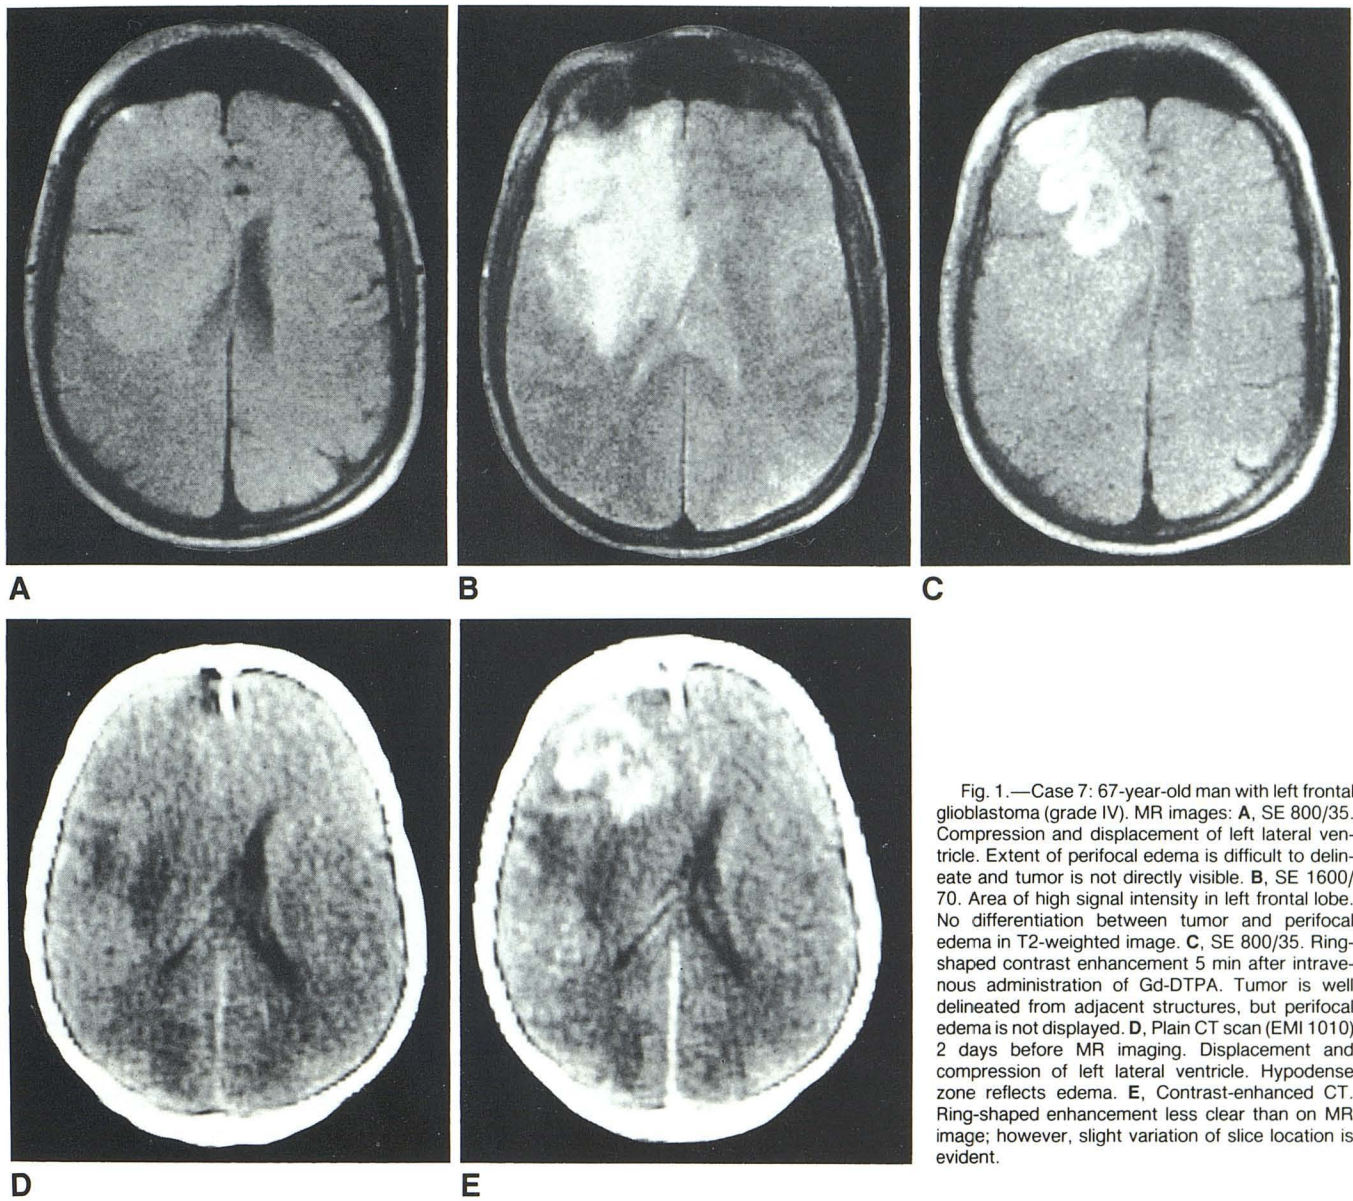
Case 7: 67-year-old man with left frontal glioblastoma (grade IV). MR images: A, SE 800/35. Compression and displacement of left lateral ventricle. Extent of perifocal edema is difficult to delineate and tumor is not directly visible. B, SE 1600/70. Area of high signal intensity in left frontal lobe. No differentiation between tumor and perifocal edema in T2-weighted image. C, SE 800/35. Ring-shaped contrast enhancement 5 min after intravenous administration of Gd-DTPA. Tumor is well delineated from adjacent structures, but perifocal edema is not displayed. D, Plain CT scan (EMI 1010) 2 days before MR imaging. Displacement and compression of left lateral ventricle. Hypodense zone reflects edema. E, Contrast-enhanced CT. Ring-shaped enhancement less clear than on MR image; however, slight variation of slice location is evident.
